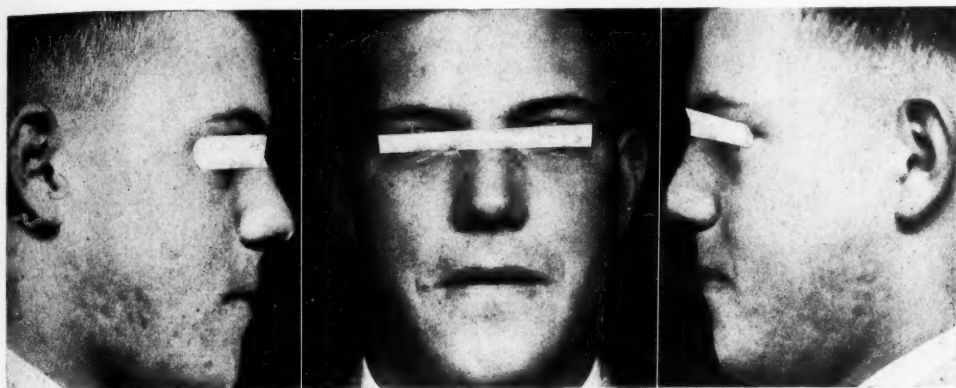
Unretouched picture of same case three months later. Treatment limited to the x-ray.
